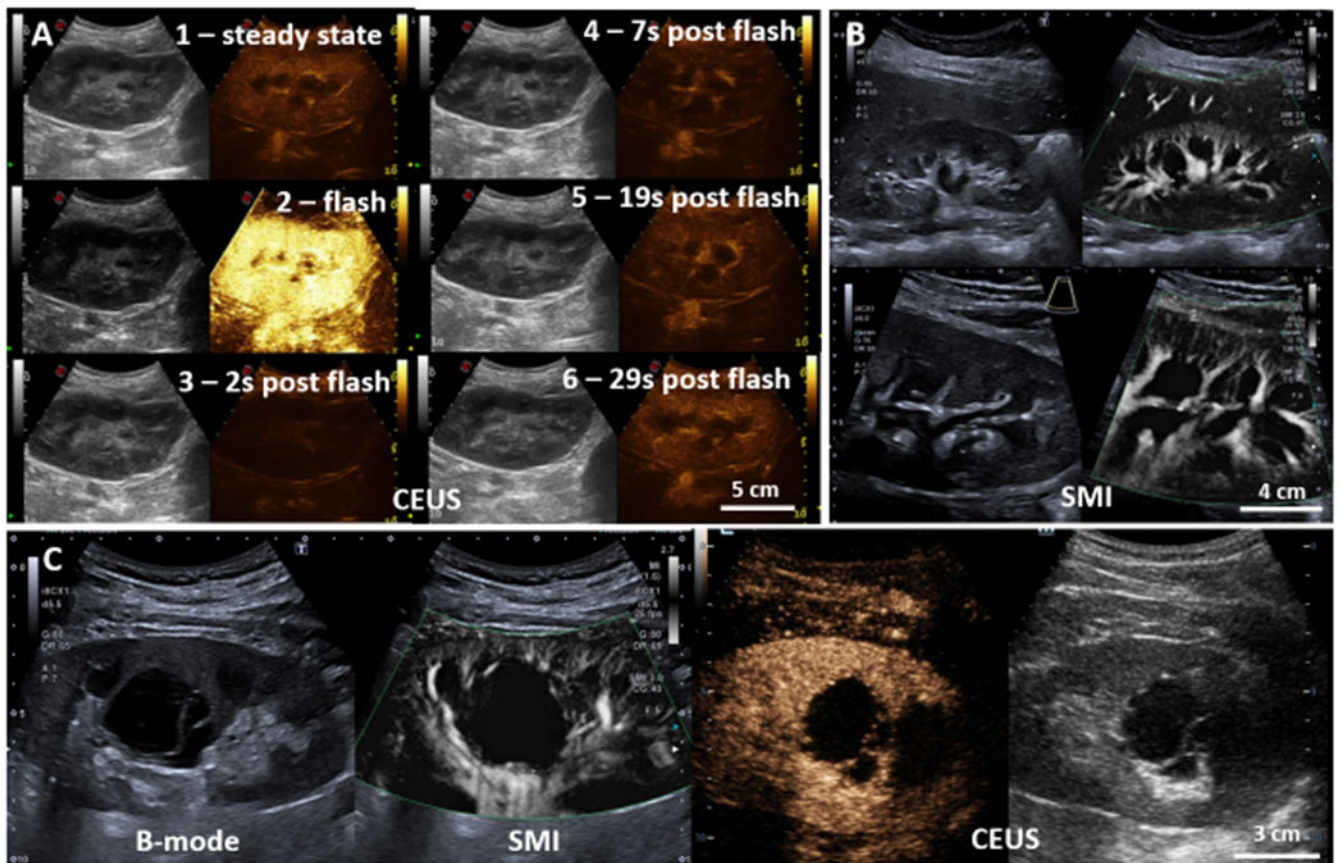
Latest ultrasound developments in the human kidney.
